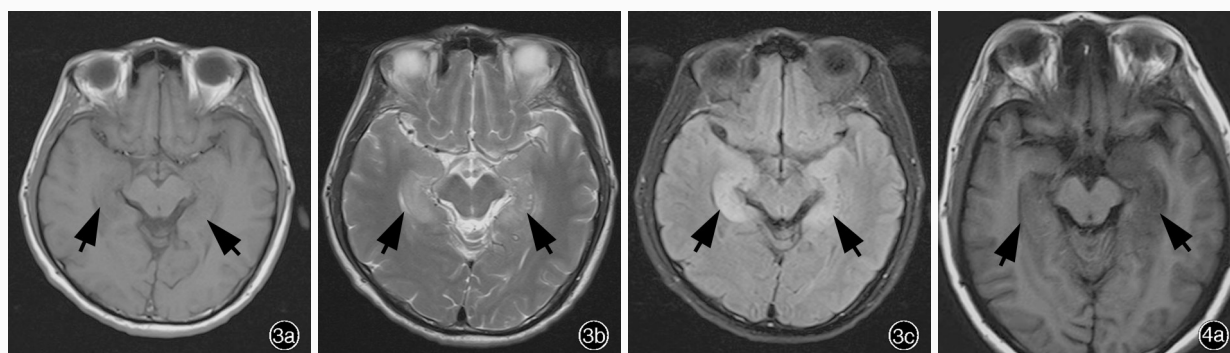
男性患者,52岁。临床诊断为抗 LG11 抗体相关边缘性脑炎。头部 MRI 检查所见 3a 横断面增强 T₁WI 显示,双侧颞叶海马稍肿胀,呈对称性低信号影(箭头所示),病灶无强化 3b 横断面 T₂WI 显示,双侧颞叶海马稍肿胀,呈对称性高信号影(箭头所示) 3c 横断面 FLAIR 成像病变呈高信号(箭头所示)
